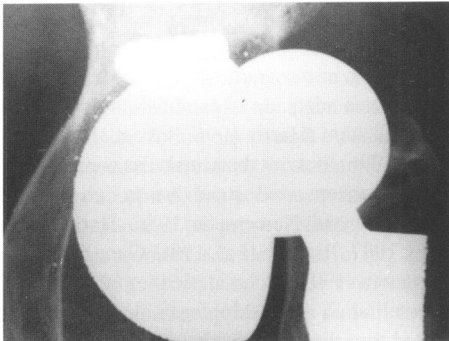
Postoperative failure of components. Rotation of acetabular component due to loosening, 7-years postoperatively in a 71-year-old man (above). Note the appearance of metal heads. 6-year postoperative radiograph showing radiolucency in the bone-cement interface in all zones in a 62-year-old woman, with loosening of the femoral component (right).
